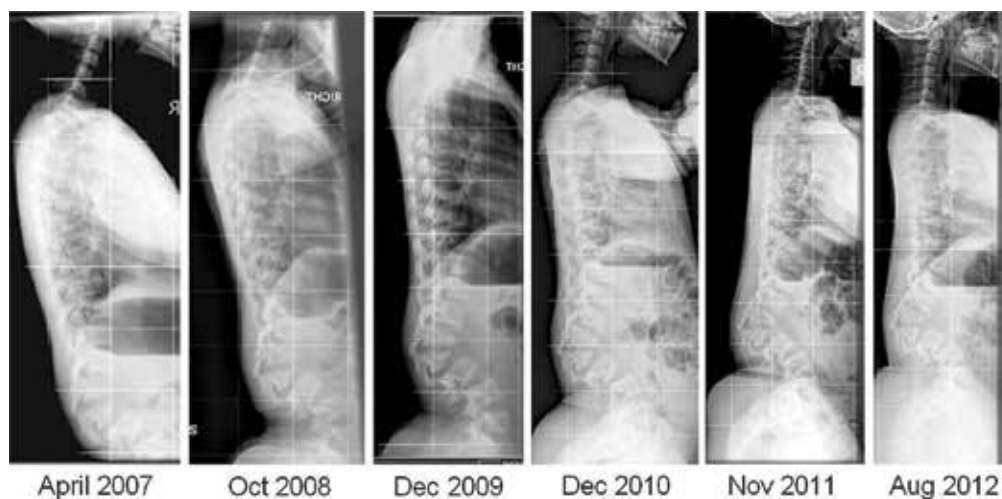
Case 1: whole spine lateral X-rays showing progression of TLK and sagittal profile.
